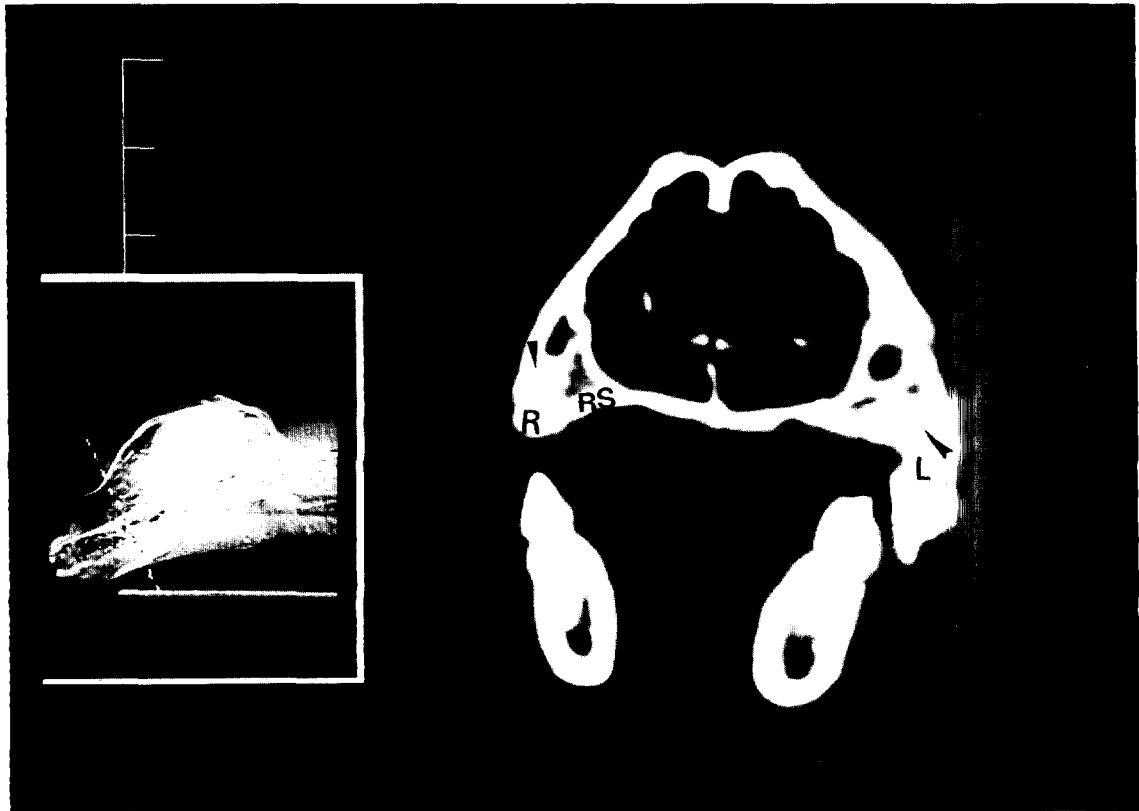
CT scan taken 4 months following left sinus (L) grafted with TGF- β /OsteoGen, and right sinus (R) grafted with autogenous/OsteoGen, showing increase in mineralization with time (arrow). residual maxillary sinus (RS).
